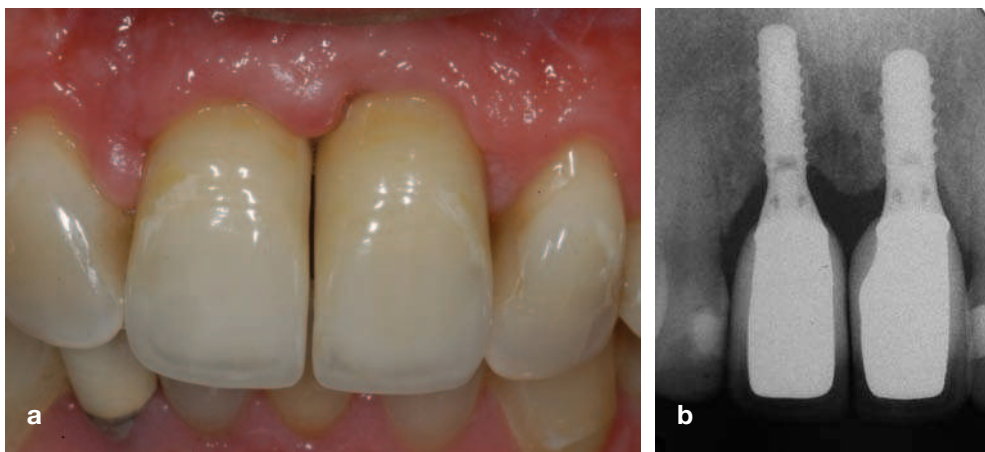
(a) Labial view of two adjacent implants replacing 11 and 21. Note the elongated contact region, and shortened inter-implant papilla. (b) Radiograph of the implants as seen in Fig 4(a). Although adequately separated, the blunting of the crestal bone between the two implants is evident.
